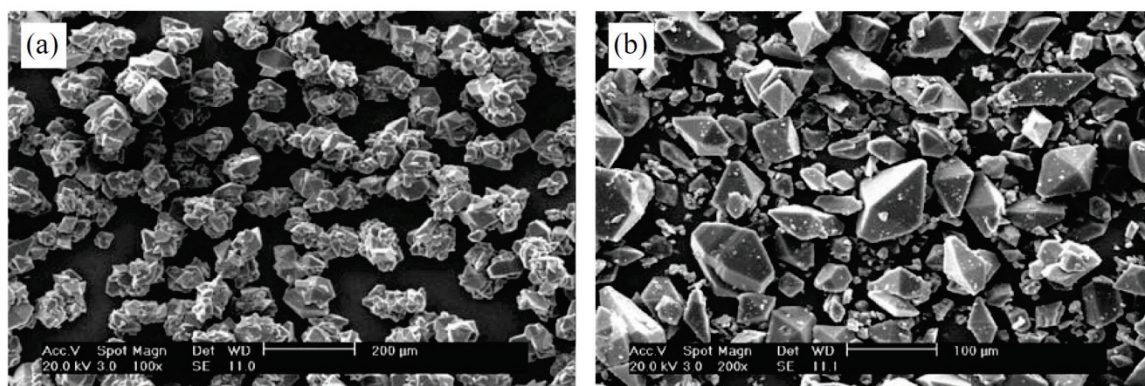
Sonocrystallization of roxithromycin. Crystals grown without ultrasound (a) and with ultrasound (b).¹⁴⁴
